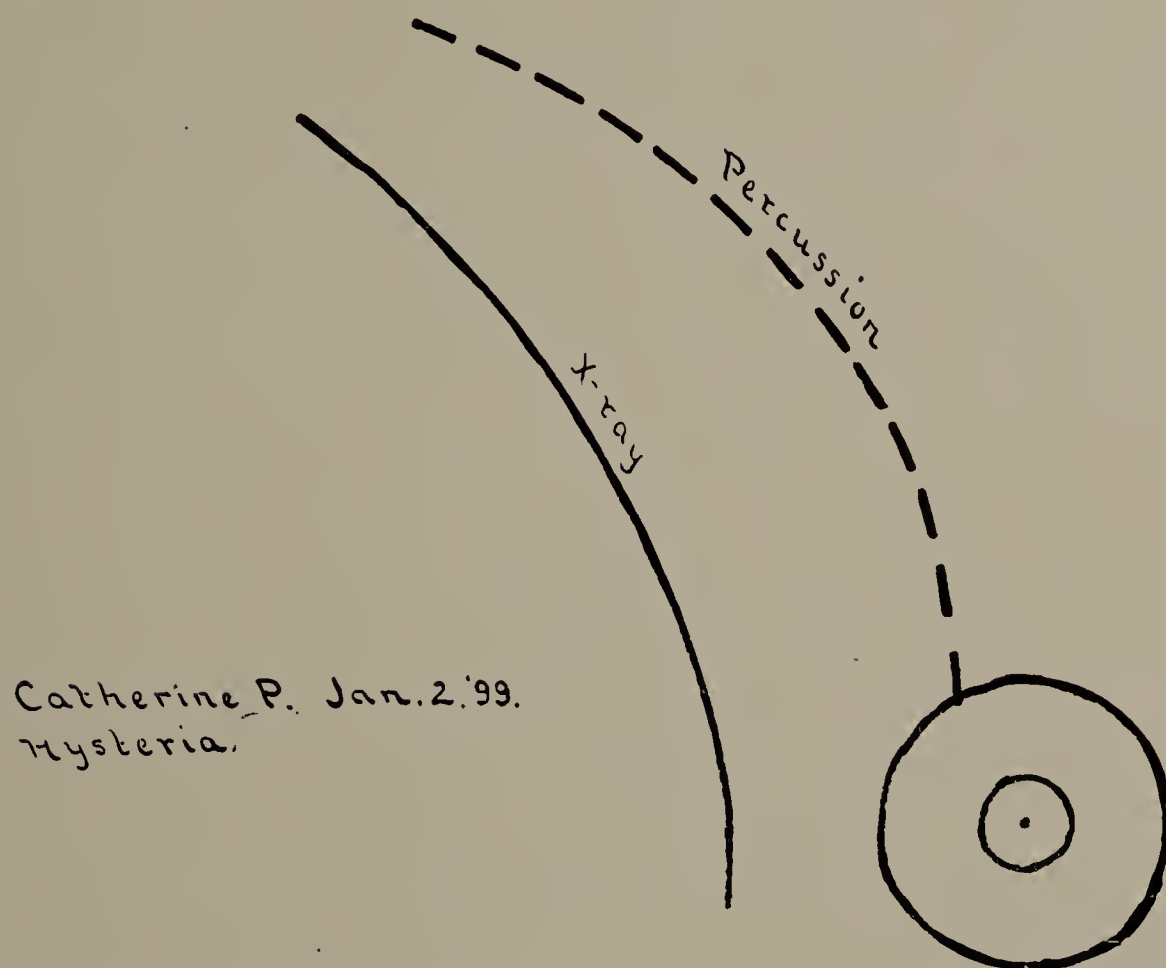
Catherine P. January 2, 1899. X-ray tracing. Full line shows position of left border of heart; broken line, its position as determined by percussion. (Cut one-third life size.)
